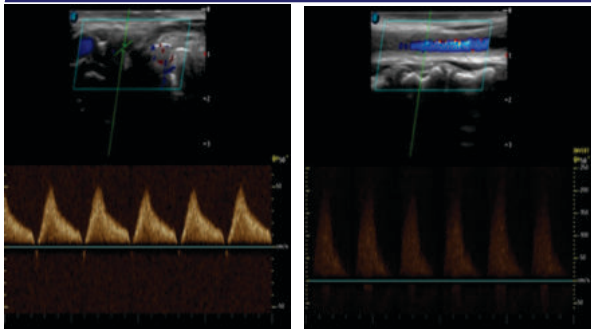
CASE 1: Spectral doppler of both the carotid arteries shows slightly high resistance flow across the involved vessels with hemodynamic parameters being within normal limits.
